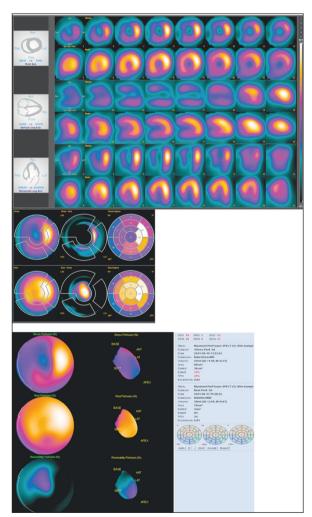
Myocardial perfusion scintigraphy provides assignment of the 17 myocardial segments to the territories of the left anterior descending artery, left circumflex artery and right coronary artery. GLS: Global longitudinal strain.
